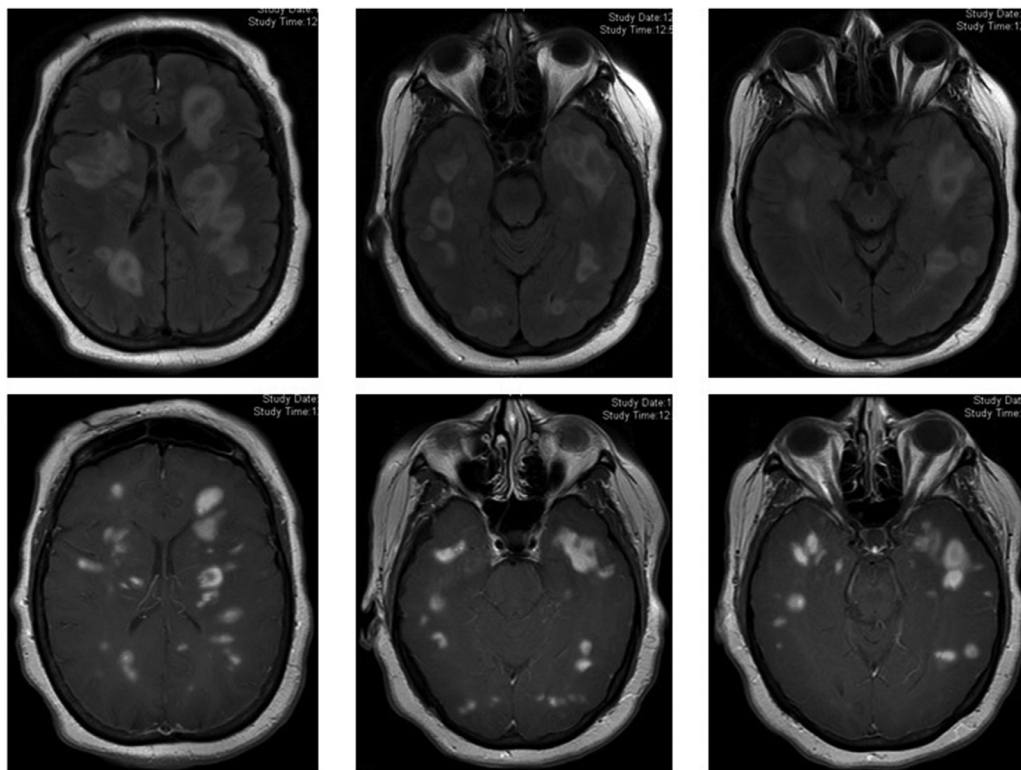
MRI Brain FLAIR sequences (top row) and images after administration of contrast (bottom row) during initial presentation with encephalopathy. Evidence of numerous enhancing T1 hypointense lesions with surrounding edema in the bilateral supratentorial, periventricular, and subcortical white matter.
